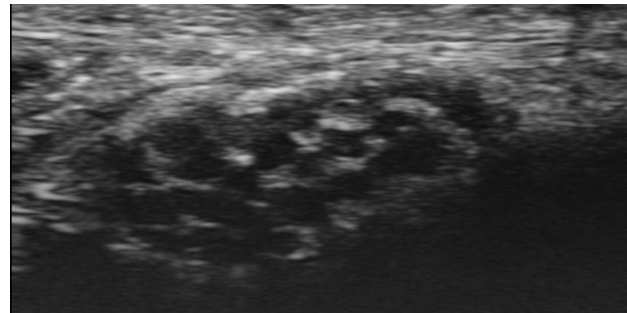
70 MHz Ultra-high frequency ultrasound image of median nerve at the wrist showing individual fascicles.
